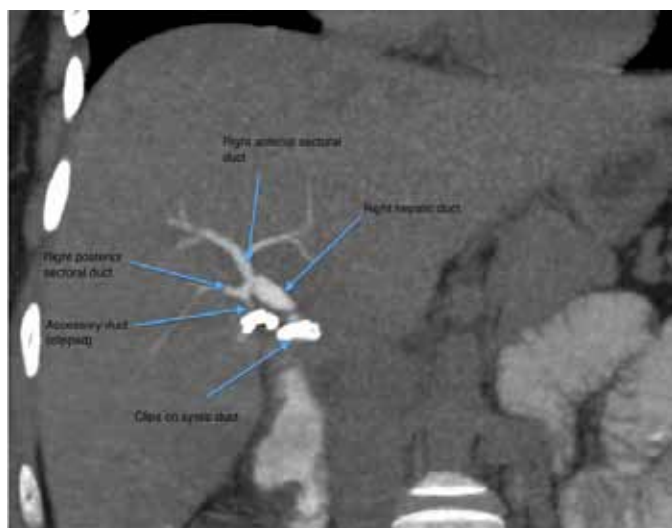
Postoperative computed tomography cholangiogram showing accessory duct clipped.
